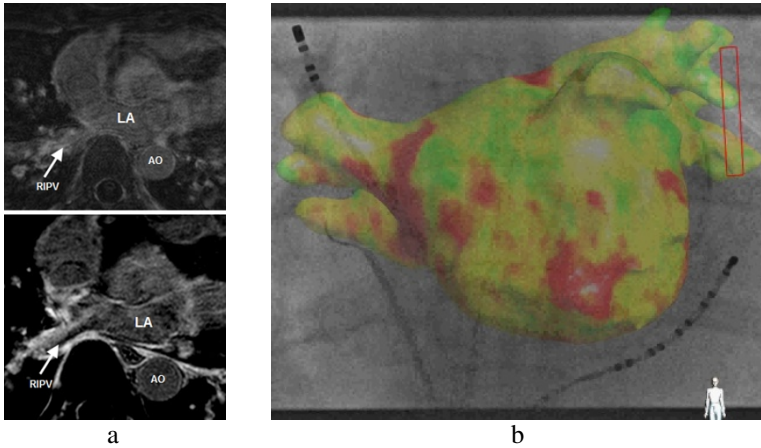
(a) Example of left atrial Gadolinium delayed enhancement MR images; (top) pre-ablation; (bottom) post-ablation showing enhancement around the pulmonary veins. (b) Left atrial surface model with color-code scar information (red is scar) generated using maximum intensity projection of DE-MRI intensity to left atrial surface along surface normals [3]. The model is superimposed onto live X-ray fluoroscopy data to guide a redo ablation procedure.
